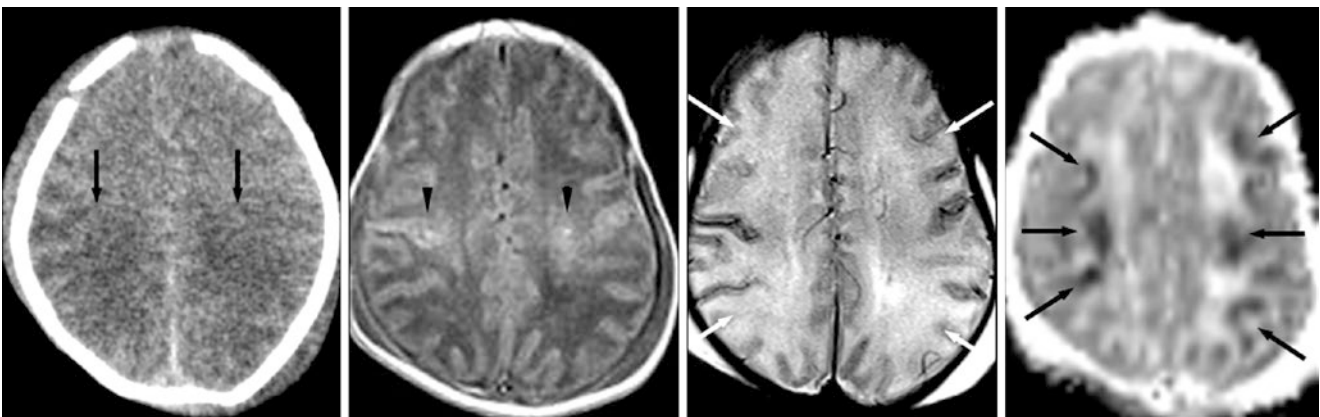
Comparison case of hypoxic-ischemic injury (HII). A 3-day-old term neonate had a CT scan (*left*) that showed subcortical low attenuation with loss of cerebral sulci posteriorly, and loss of gray-white matter differentiation called cerebral edema. A 3T MRI depicted patchy periventricular hyperintensity (*arrowheads*) on gradient
